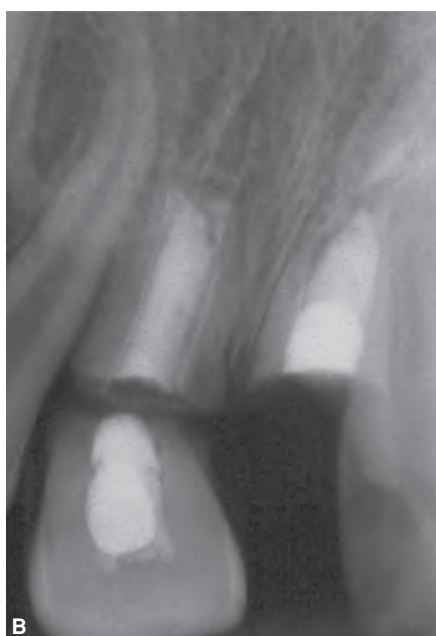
Radiographs show maxillary central incisors that were subjected to a traumatic incident. A. Teeth are splinted shortly after injury. B. Eighteen-month follow-up radiograph shows cervical root fractures in both teeth subsequent to apexification. (Courtesy of Dr. Leif K. Bakland, Loma Linda, CA, U.S.A.)
